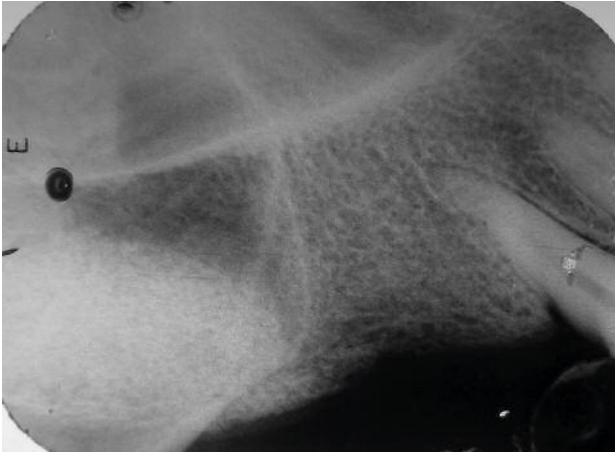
X-ray immediately post-op showing the location of the β -Tricalcium Phosphate on the maxillary sinus floor -radiolucent area- (day 0).
